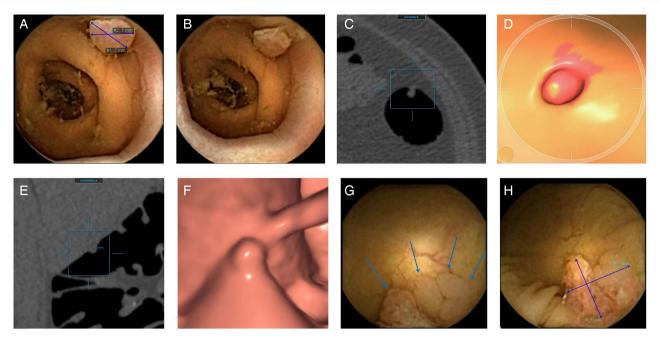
False positive cases. Case 1: a 7 mm polyp detected in the sigmoid by colon capsule endoscopy (CCE) (A and B) and CT colonography (CTC) ((C) axial two-dimensional (2D) CT image and (D), 3D endoluminal view after application of computer-aided detection (CAD)). This polyp was not confirmed by colonoscopy and it was considered a false positive case. Case 2: a 6 mm polyp detected by CTC ((E) coronal 2D CT image 3D endoluminal view and (F), 3D endoluminal view) at the hepatic flexure. This polyp was not visualised by CCE and colonoscopy (CTC false positive). Case 3: a 13 mm lesion detected in the proximal ascending by CCE ((G) and (H)). This lesion was not confirmed by colonoscopy and it was considered a CCE false positive case.
